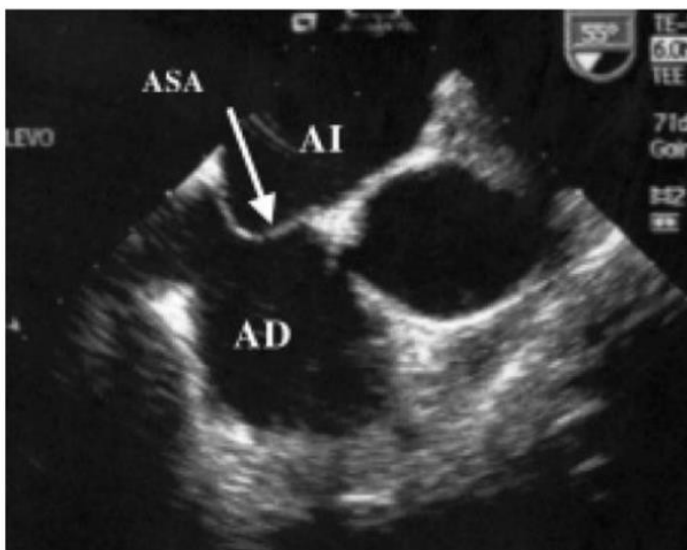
Echocardiogram showing atrial septum aneurysm (ASA) (arrow) in a patient with PFO. RA: right atrium and LA: left atrium. (Extracted from Montas de Oca¹).
